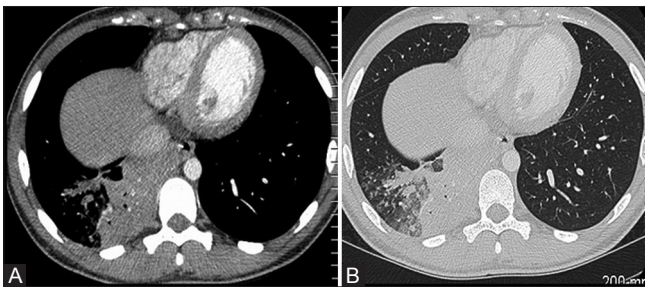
(A and B): Axial contrast enhanced CT chest images in case 1 show consolidation in the right lower lobe (A and B). Blastomycosis was confirmed at bronchoalveolar lavage
